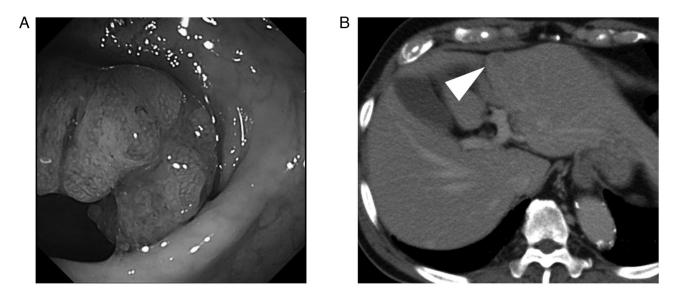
Clinical images of case 4. (A) Preoperative colonoscopy revealed a polypoid mass in the sigmoid colon in case 4. (B) Computed tomography revealed liver metastases 8 months after surgery (17 mm in long diameter in S3; white arrowhead).
